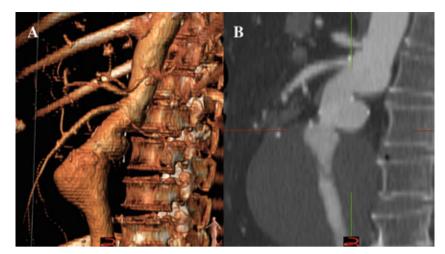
Preoperative CTA: 8cm pararenal AAA with complex proximal neck anatomy (Panel A, 3D reconstruction, Panel B, Longitudinal axis)
